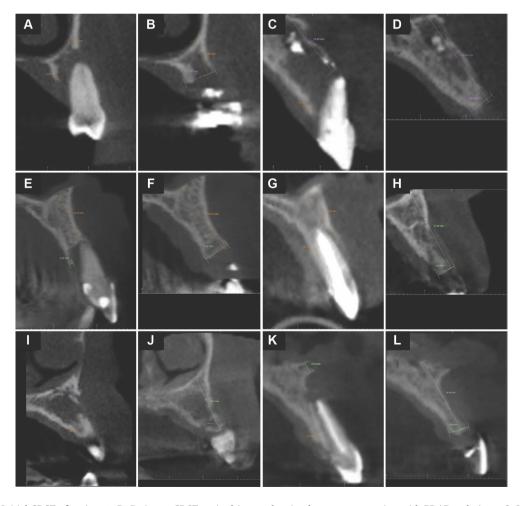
A: Initial CBCT of patient 1; B: Patient 1 CBCT sagittal image showing bone reconstruction with PDAR technique; C: Initial CBCT of patient 2; D: Patient 2 CBCT sagittal image showing bone reconstruction with PDAR technique; E: Initial CBCT of patient 3; F: Patient 3 CBCT sagittal image showing bone reconstruction with PDAR technique; G: Initial CBCT of patient 4; H: Patient 4 CBCT sagittal image showing bone reconstruction with PDAR technique; I: Initial CBCT of patient 5; J: Patient 5 CBCT sagittal image showing bone reconstruction with PDAR technique. K: Initial CBCT of patient 6; L: Patient 6 CBCT sagittal image showing bone reconstruction with PDAR technique.
